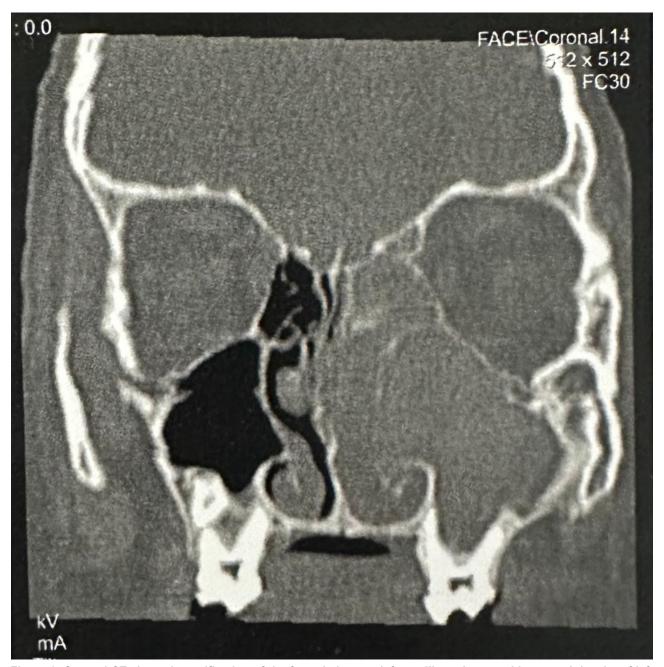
Coronal CT showed opacification of the frontal sinuses, left maxillary sinus, and increased density of left ethmoid cells, as well as evidence of bone remodeling. There was also a deviation of the nasal septum to the right and extensive involvement of the frontal sinuses, left maxillary sinus, and ethmoid cells, extending into the nasal fossa, with an expansive appearance and dense content causing ipsilateral anterior bulging at the medial anterior ethmo-orbital margin, displacing the retro-medial muscle and adjacent orbital fat, impinging upon the eyeball.
